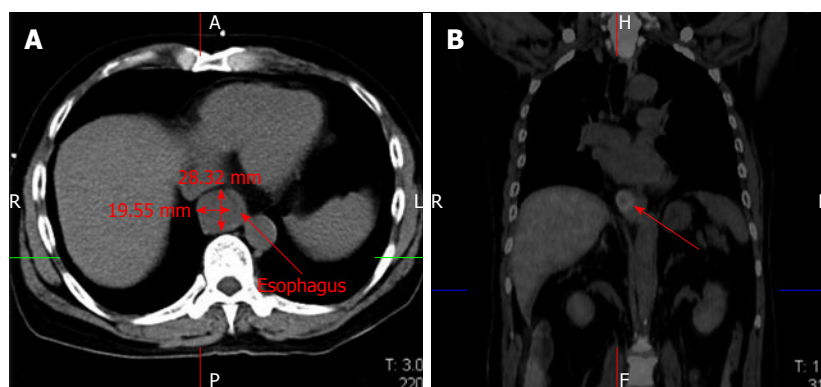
Computed tomography scan demonstrated marked thickening of the esophageal wall (A). Positron emission tomography scan showed marked uptake by the esophageal lesion without any recurrence of hepatocellular carcinoma at other sites (B).
